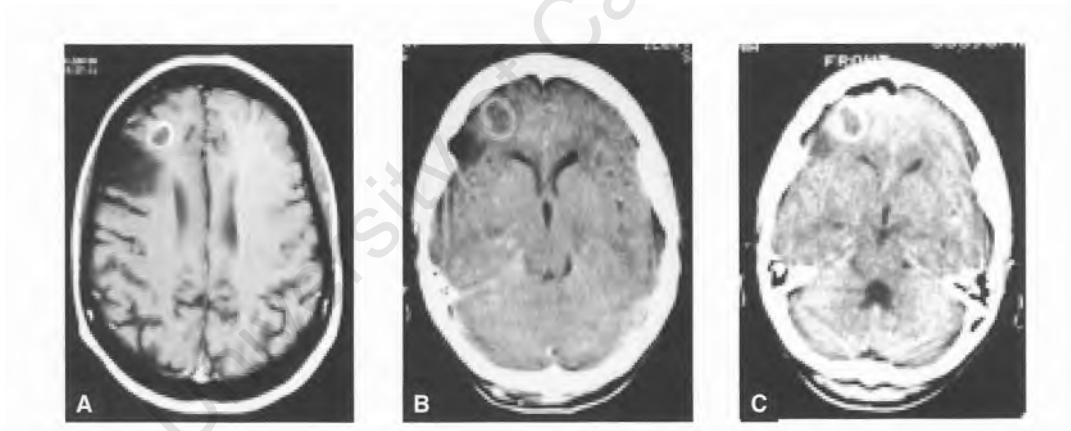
Axial T1 MRI scan (a) and CT scan, both with IV contrast, show a right frontal subcortical ring-enhancing lesion adjacent to an infarct. Following aspiration, the lesion was smaller on the postoperative scan (c), which also demonstrated an adjacent locule of subdural air.
